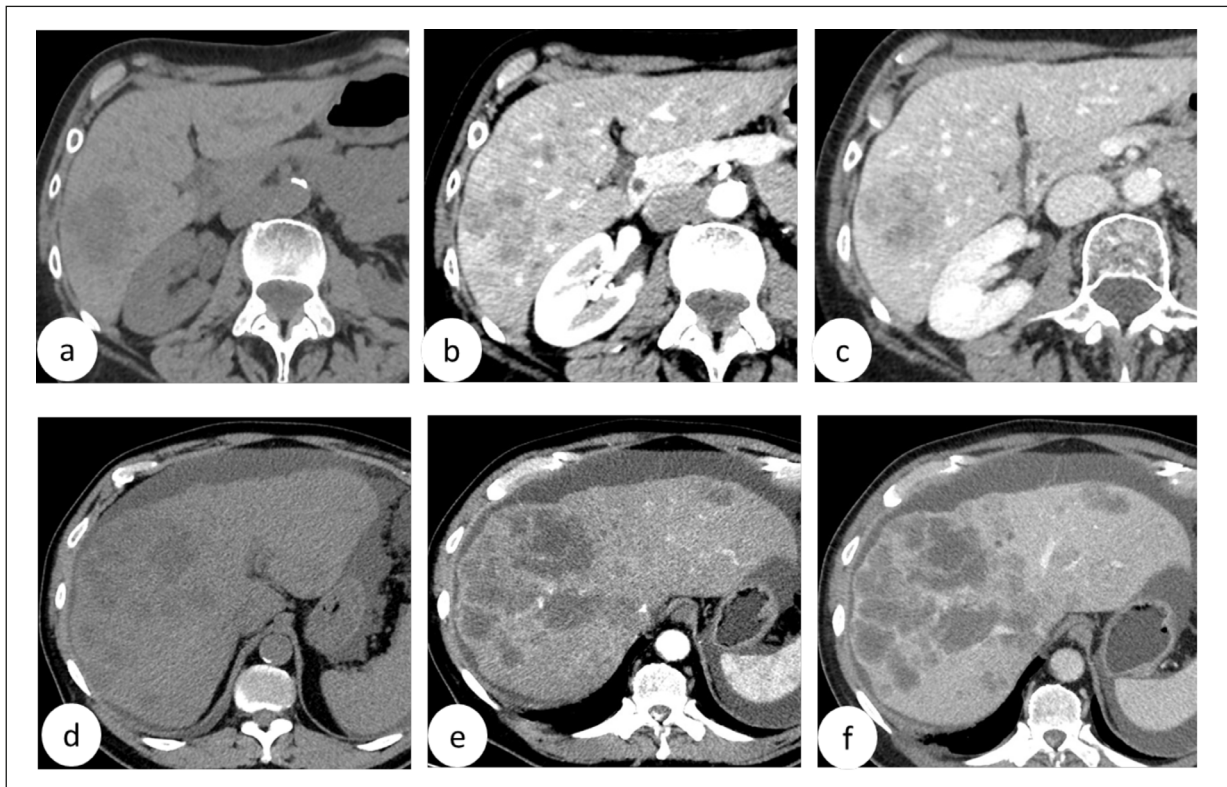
Liver metastases: breast (a-c), and colorectal cancer (d-f) on CT. Basal acquisition (a,d). Contrast study: late arterial (b,e), and portal venous (c,f) phases. Liver metastases from breast adenocarcinoma show heterogeneous hyperenhancement mainly on the periphery with perilesional enhancement (a-c). Colorectal liver metastases (d-f) appear mostly hypovascular with hypodense, non-enhancing areas giving the appearance of complex cyst.
